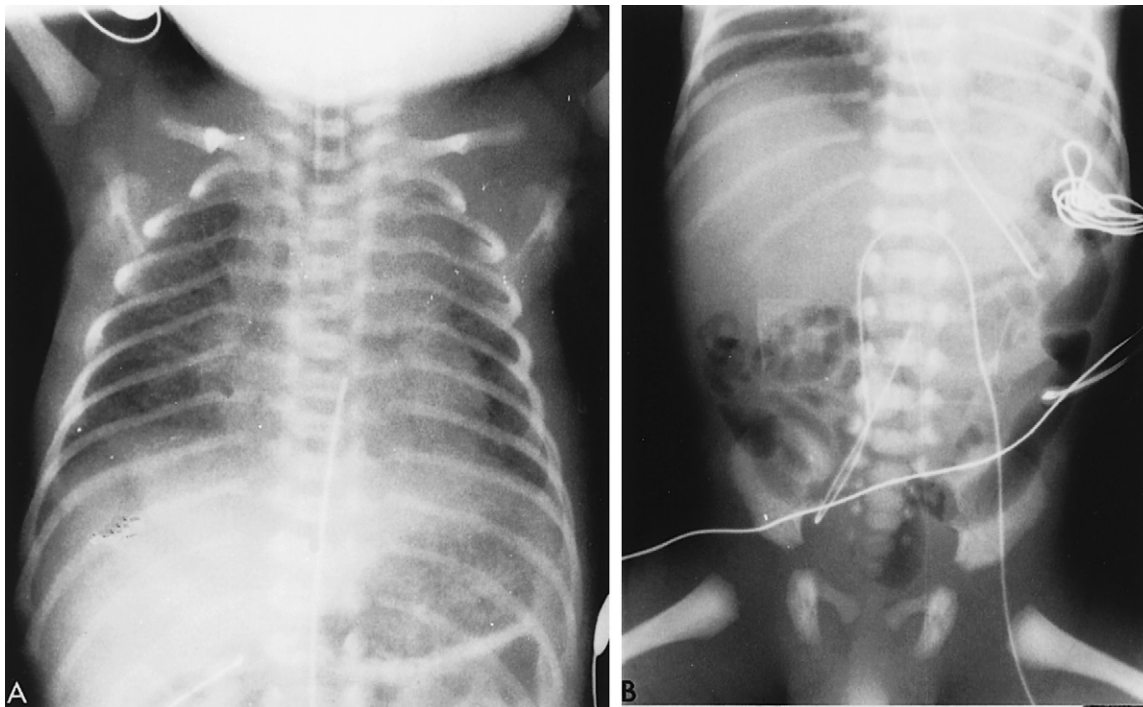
■ A, X-ray film showing umbilical artery catheter in “high” position. B, X-ray film showing umbilical artery catheter in “low” position.
